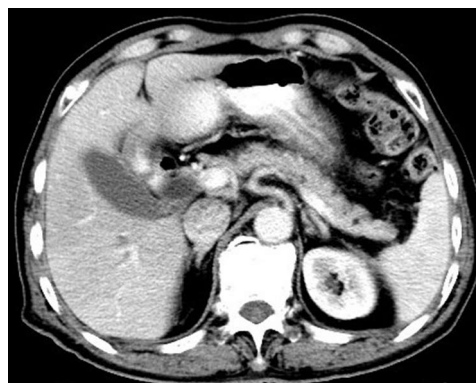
Computed tomography in August 2014 also showing the normal pancreas.
